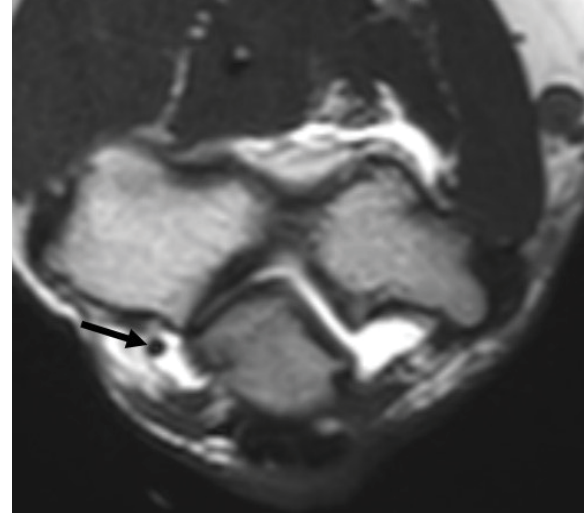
Axial T1-weighted image: intra-articular loose body in the postero-medial capsular recess (black arrow).
